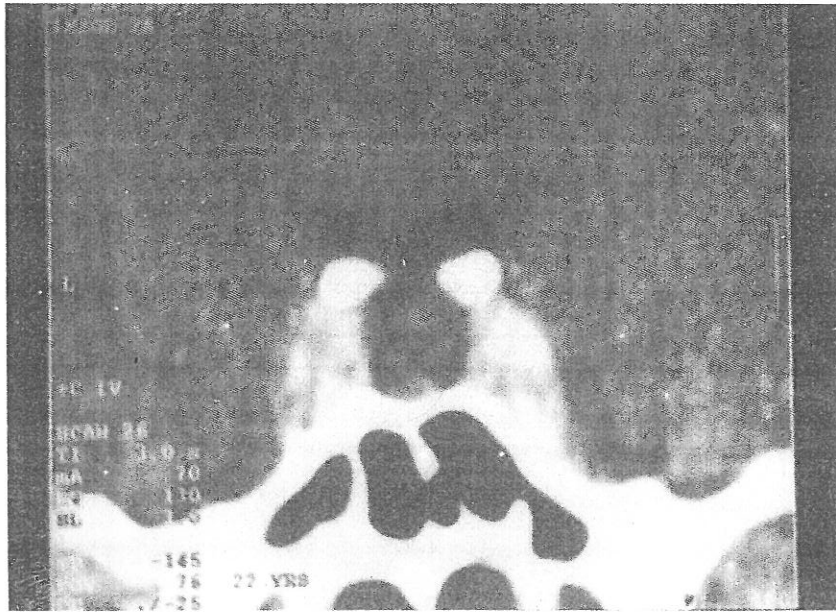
Coronal CT scan showing hypodense intrasellar area
